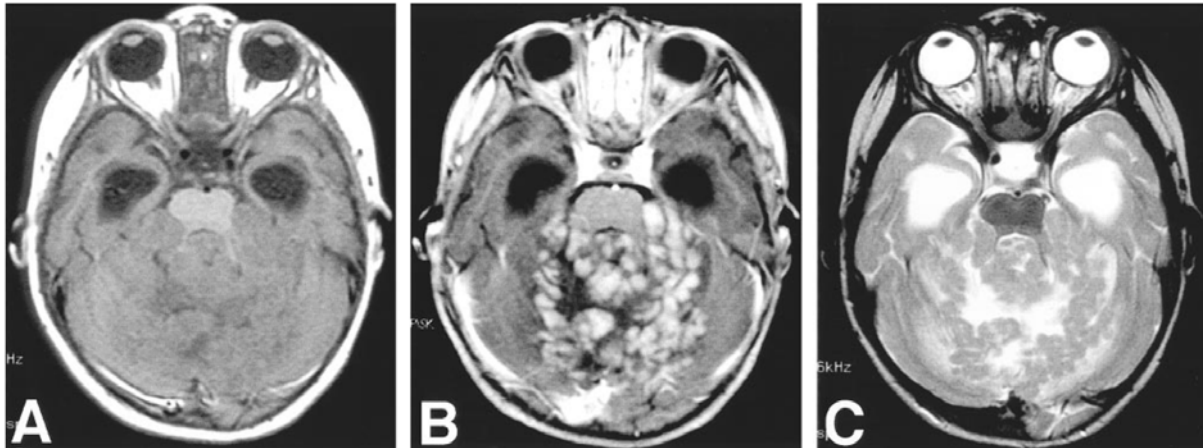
Axial view MR images show an equivocal nodularity with surrounding high T2-weighted signal intensity in the tumour. A, T1-weighted image (380/10/2 [TR/TE/NEX]). B, Contrast-enhanced T1-weighted image (380/10/2) reveals a grape-like enhancing tumour occupying the upper part of the posterior fossa. C, T2-weighted image (4500/100/2). From Yuichiro et al., 2002¹⁰
